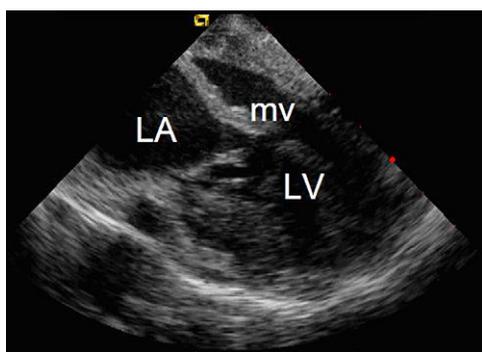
An intracardiac ultrasound from a patient who had MS. Note the thickening of the anterior leaflet, the small chamber size, and the normal LV wall thickness. During systole, there was normal chamber contraction and normal wall thickening. Often, LV systolic function is normal and, even when the ejection fraction is somewhat reduced in MS, it does not appear to impact on surgical mortality. LA, left atrium; MV, mitral valve.
